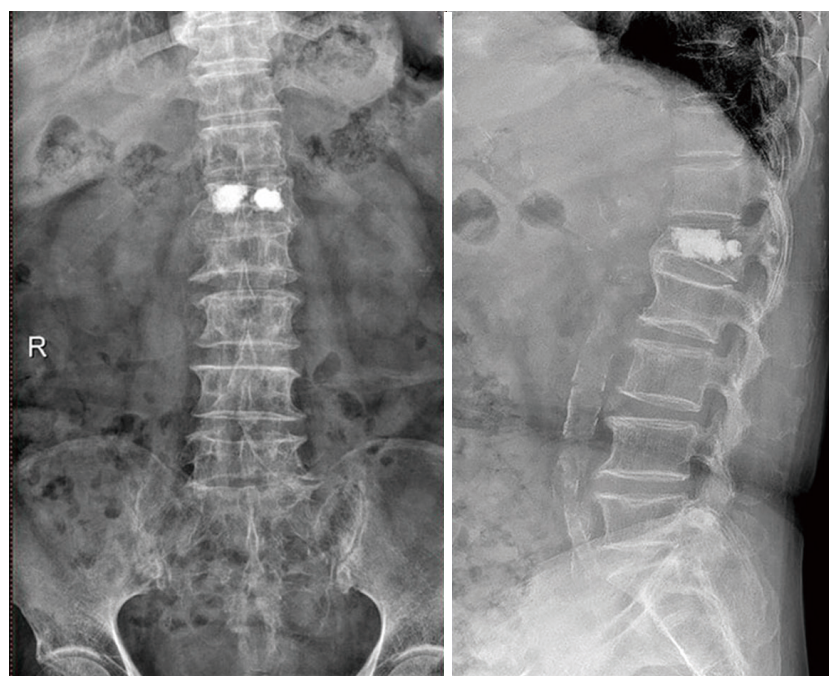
Preoperative X-ray showing the changes of L1 after and L2 vertebral fracture.
